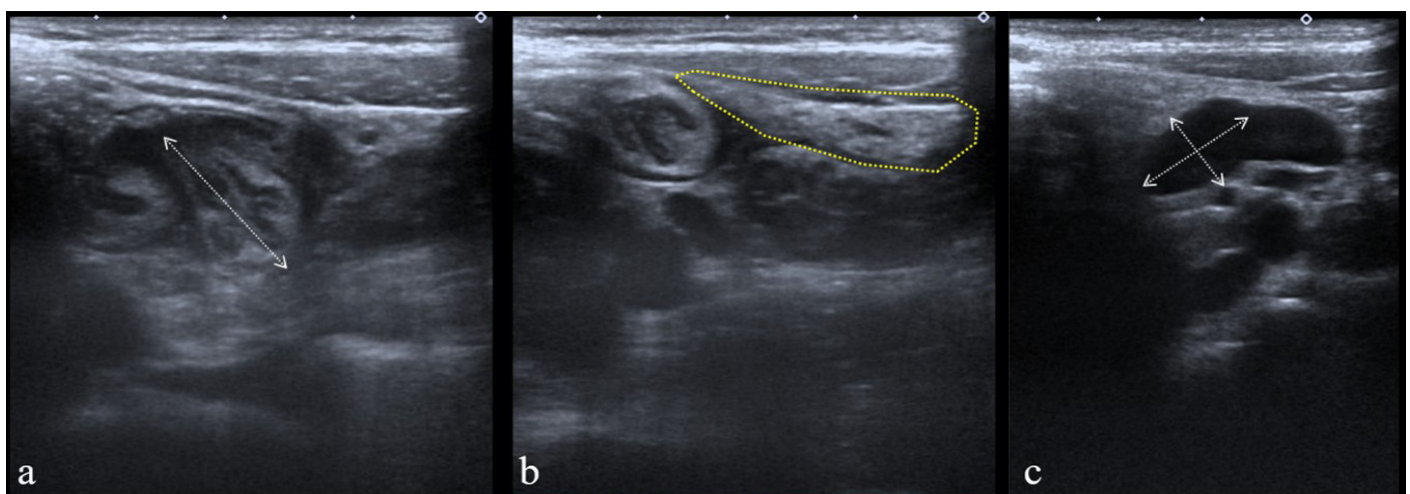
Ultrasonographic findings of a 7-month-old female patient. a) Ileocolic intussusception measuring 35 mm in length (white dashed arrow) and b) increased inflammatory echogenicity in the adjacent mesentery (yellow shaded area). c) Adjacent mesenteric lymph nodes are seen near the intussuscepted segment. The larger lymph node measures 8x13 mm in size (white dashed arrows). Hydrostatic reduction was successful in this patient
